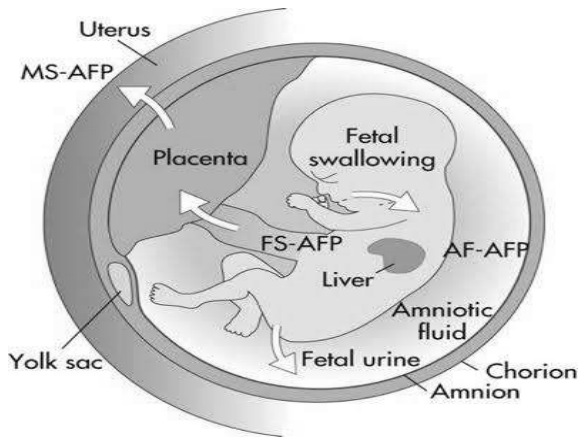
Robbin M, Filly RA, Fell S, Goldstein RB, Callen PW, Goldberg JD, Golbus MS. Elevated levels of amniotic fluid alpha-fetoprotein: sonographic evaluation. *Radiology*. 1993 Jul;188(1):165-9.
